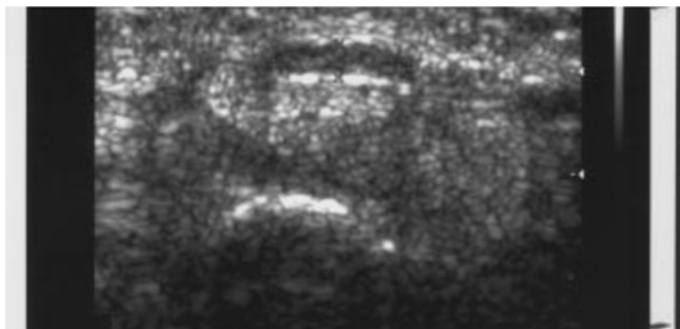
43-year-old man with carpal tunnel syndrome. Sonogram shows flattened, swollen, and hypoechoic left median nerve. Flexor retinaculum immediately superficial to nerve is seen to bow anteriorly. Caliper measurements of major and minor axes of nerve are shown. (38)
